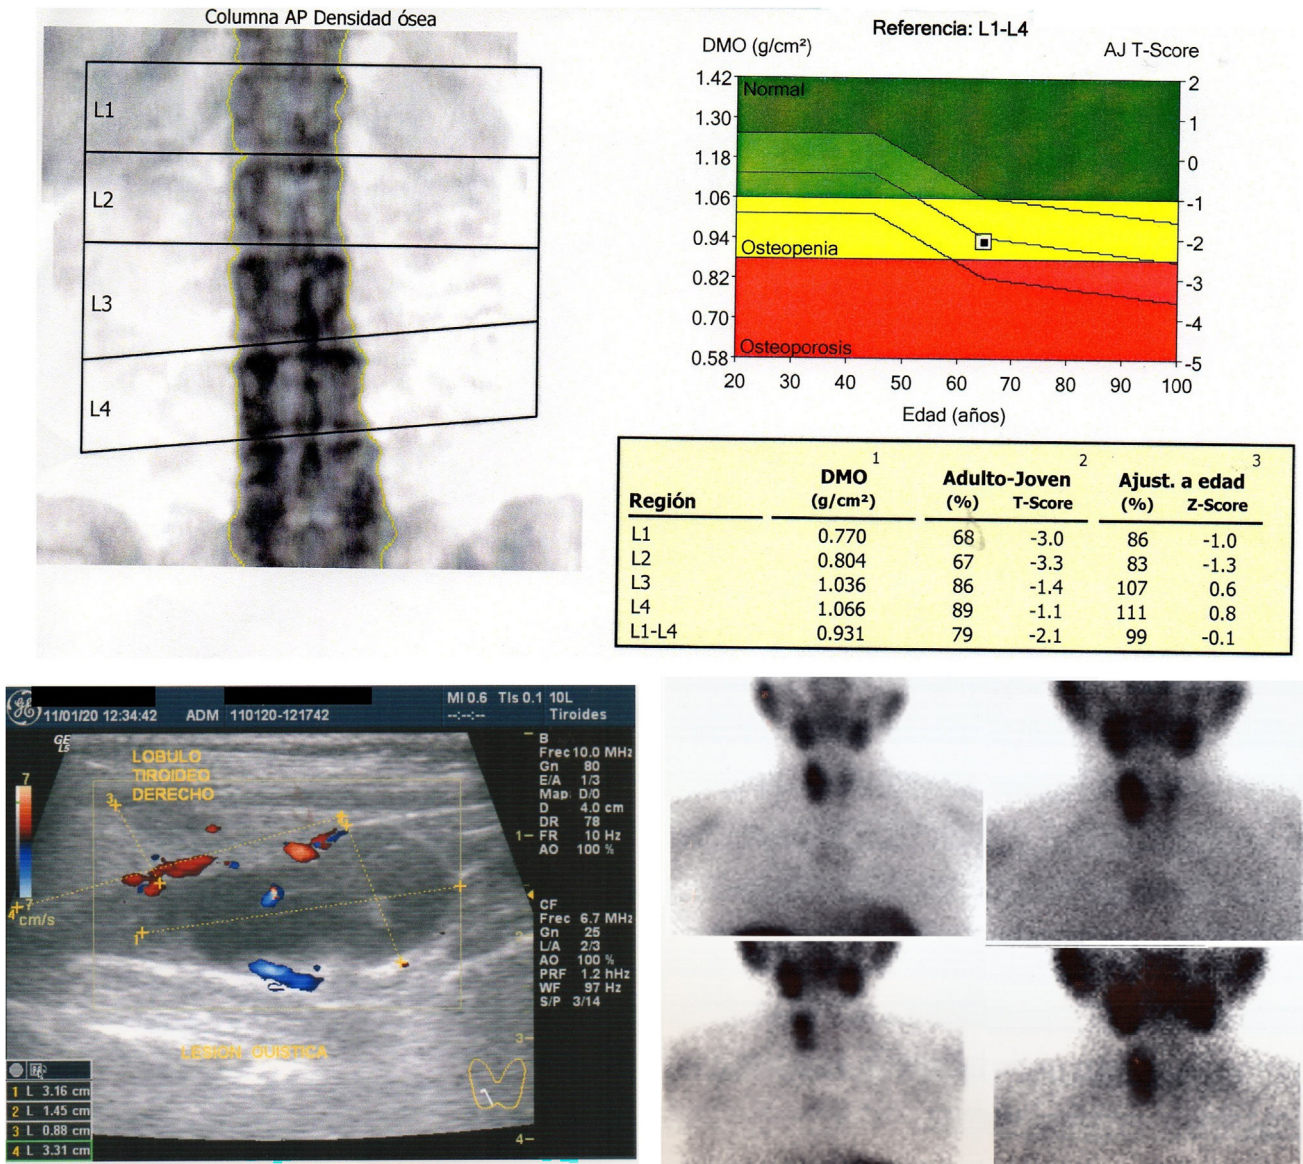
Radiological findings: densitometry with the presence of osteopenia in the spine. Neck ultrasound with suggested data of cystic lesion of the parathyroid glands. Parathyroid scintigraphy with hypercaptant nodular image in the upper pole of the right thyroid lobe and of less intensity in the lower pole of the same side.
